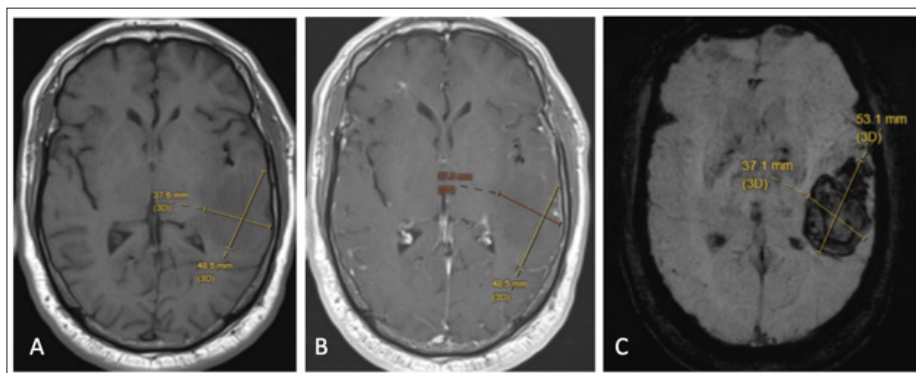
MRI Head, from Left to Right, (A) T1 without Contrast, (B) T1 with Contrast, (C) SWI sequence
